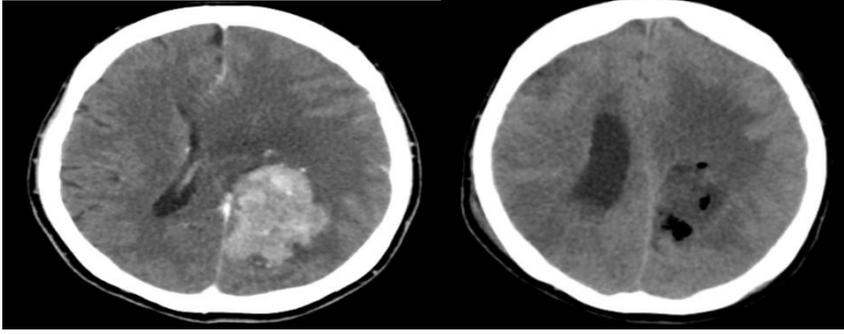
CT brain image pre operative (left) vs post operative (right).
